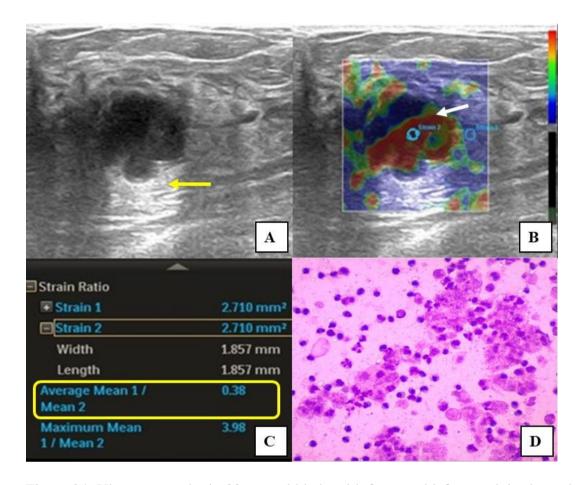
Ultrasonography in 38-year old lady with fever and left mastalgia showed a well-defined, ovoid, anechoic cystic lesion (thick yellow arrow) with echogenic debris and posterior acoustic enhancement, suggestive of BIRADS 3 lesion (Fig A). On elastography, the lesion demonstrated BGR trichromatic interface pattern (thick white arrow) in modified colour score (score 0, Fig B). Mean strain ratio was 0.38 (yellow box, Fig C). Correlating ultrasonography and elastography, a diagnosis of breast abscess was given. The same was confirmed with fine needle aspiration cytology (Fig D).
